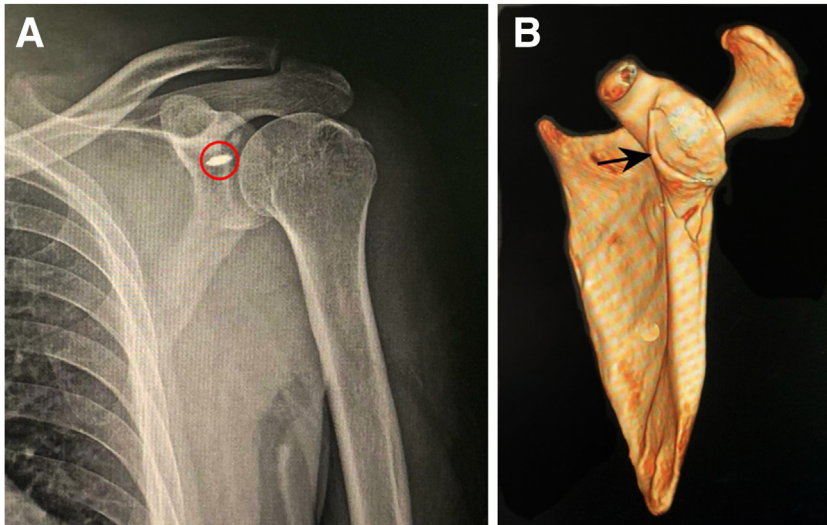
The imaging results postoperation. (a) Radiograph reveals the normal relationship between the humeral head and glenoid, with a red circle indicating the location of the anchor nail. (b) Three-dimensional computed tomography demonstrates that the gap between the bony fracture and glenoid is small, and the articular surface is smooth (black arrow).
